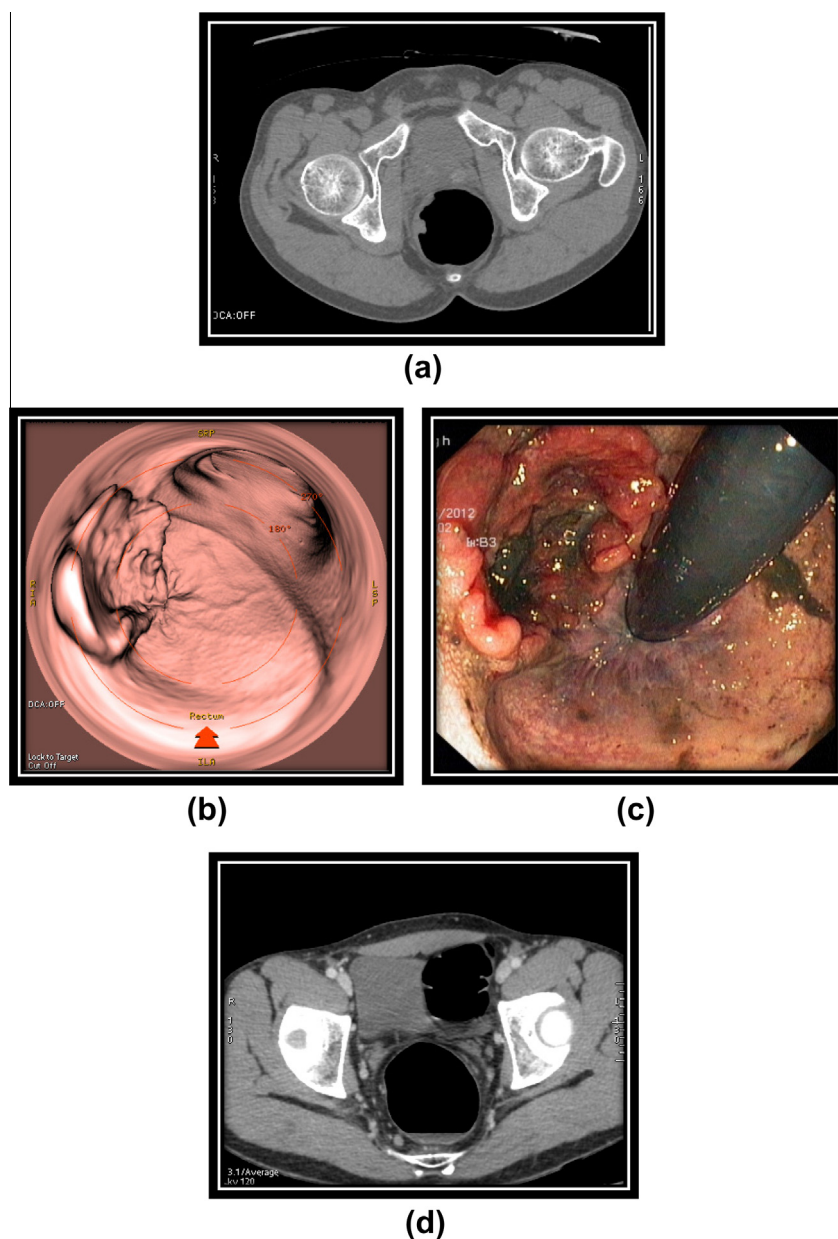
Ulceroproliferative growth involving the right lateral wall of the rectum in a 37-year-old male. (a) Axial (prone) image of CTC showing ulceroproliferative growth in the rectum (b) and (c) depicts the growth on the right lateral wall in the Virtual and Optical Colonoscopy respectively. (d) Axial (supine) CE CT image demonstrates lymphnode in the pararectal region.
